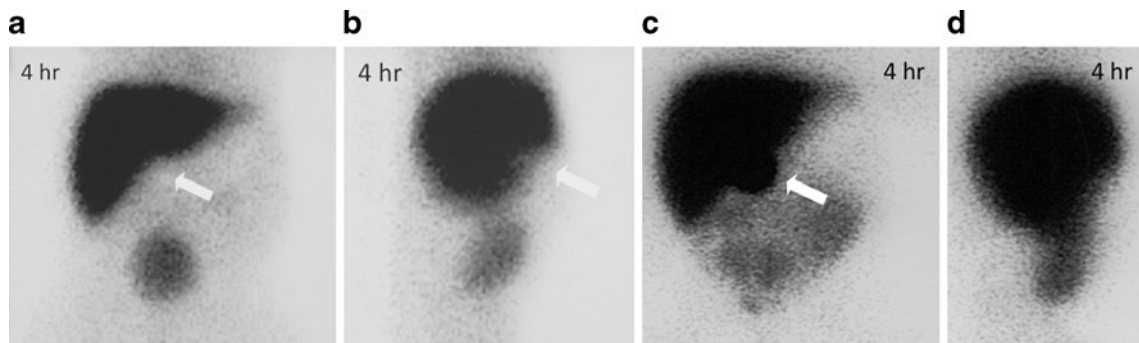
Neonatal cholestasis in a 2-month-old girl with sonographic diagnosis of choledochal cyst; hepatobiliary scan was requested to rule out associated biliary atresia. a, b Anterior and lateral 4-h delayed images of the initial hepatobiliary scan obtained after only 1 day of phenobarbital premedication demonstrate normal hepatic uptake with no excretion. Note the photopenic defect along the inferior aspect of the liver consistent with the known choledochal cyst (*arrow*). c, d
